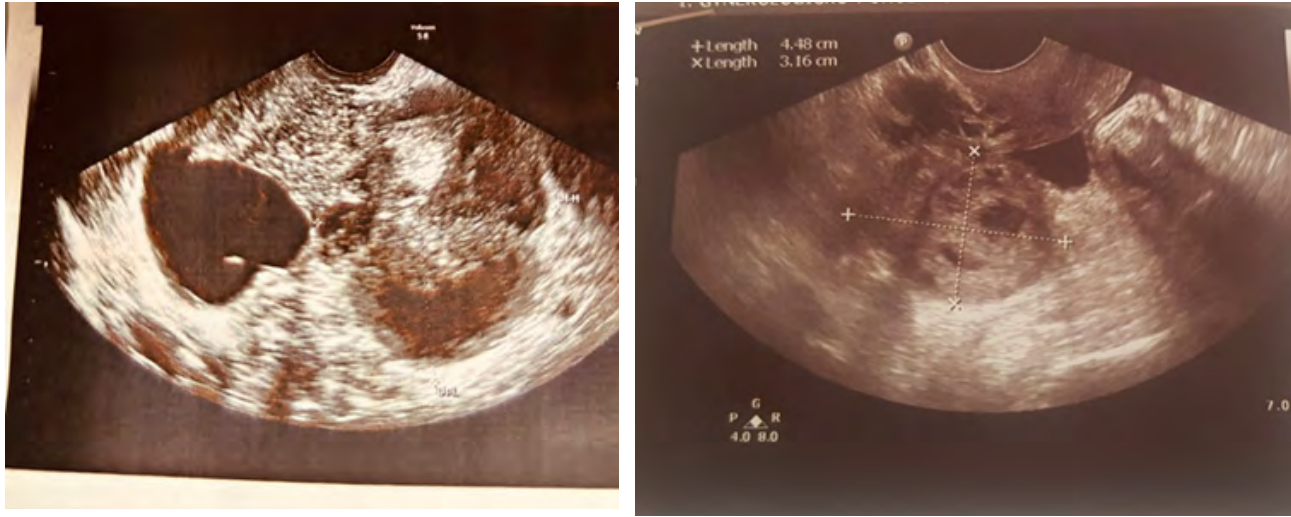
Ultrasound of the ovarian mass
